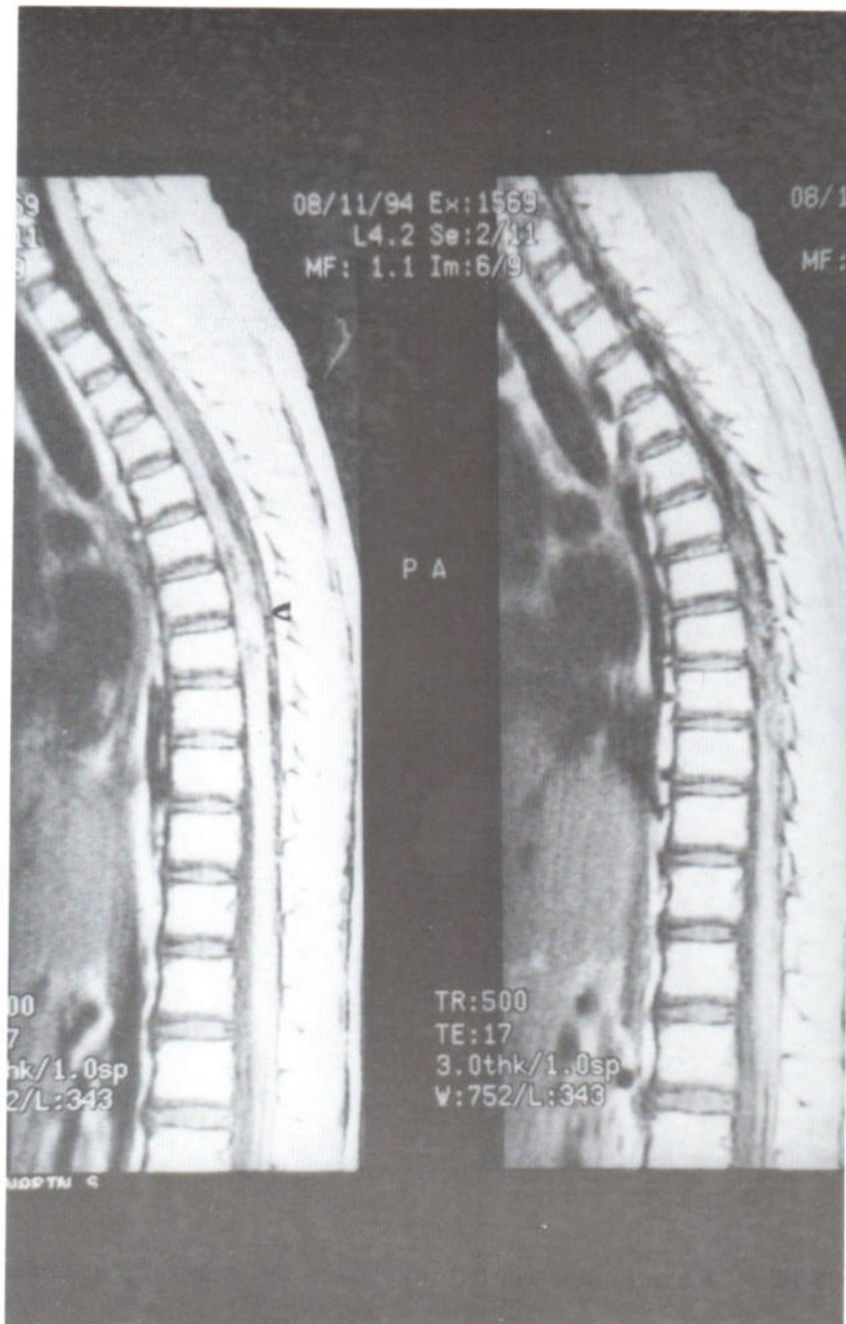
MRI sagittal T1W showed hemorrhage within the cord at level of T₆₋₇ (arrow) with dorsal tubular longitudinal flow void structures of draining veins.
